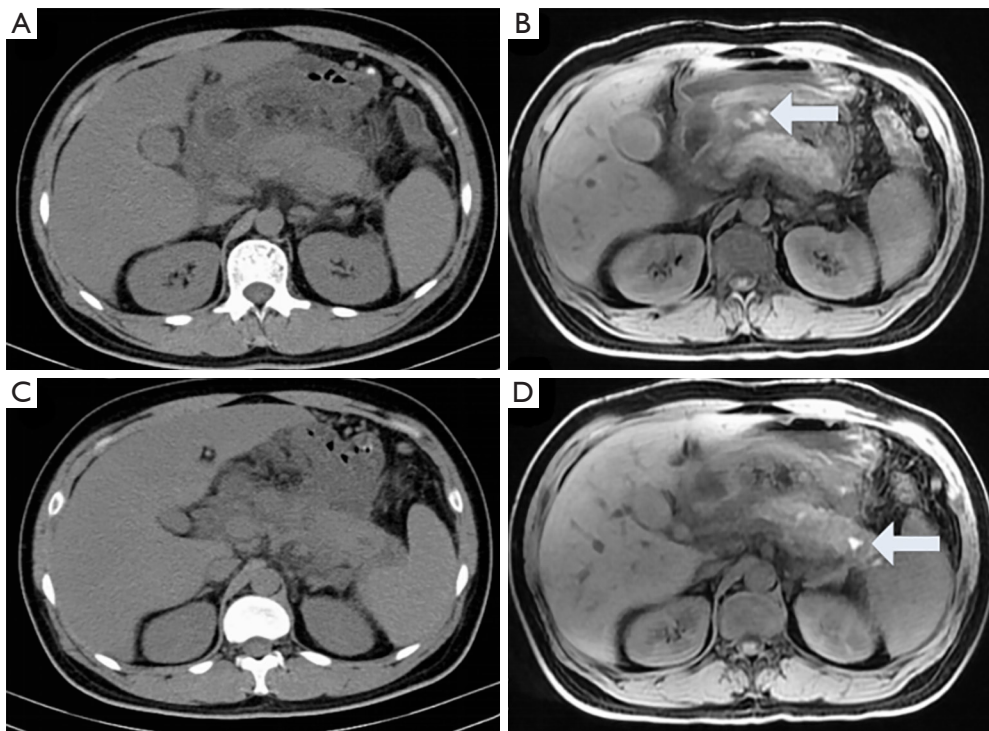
A 32-year-old female patient with acute necrotizing pancreatitis who underwent both CT (A,C) and MRI (B,D) examinations within 3 days of onset. The CT image (A,C) show an enlarged pancreas with homogeneous density and peripancreatic collections; however, the MRI T1WI (B,D) clearly shows patchy hyperintensity in the tail and around the pancreas (corresponding to hemorrhages) (arrow). MRI, MR imaging.
